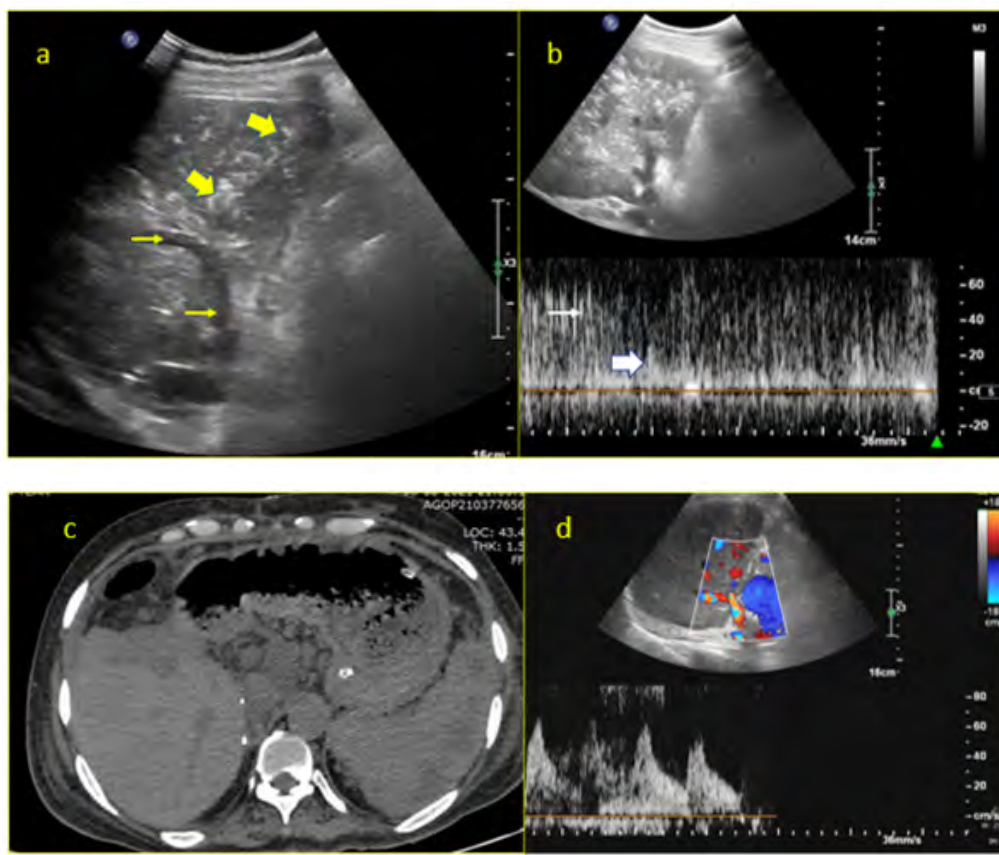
44/M (LAR-3) Post LDLT. Sonography on POD-4 (a) demonstrates low level echoes within the portal vein (yellow arrow) and multiple air echoes in the liver parenchyma (yellow block arrows). The echoes in the portal vein and its divisions were mobile towards the direction of blood flow. An attempted spectral tracing of the hepatic artery (b) shows multiple irregular spikes (white arrow) superimposed over the baseline arterial trace (white block arrow). Plain CT scan of the upper abdomen (c) on POD-5 demonstrates no air in the liver parenchyma or in the portal vein branches. Follow up doppler sonography on POD -6 (d) shows resolution of the previously noted air echoes and significant reduction in the superimposed spikes over the arterial trace.
